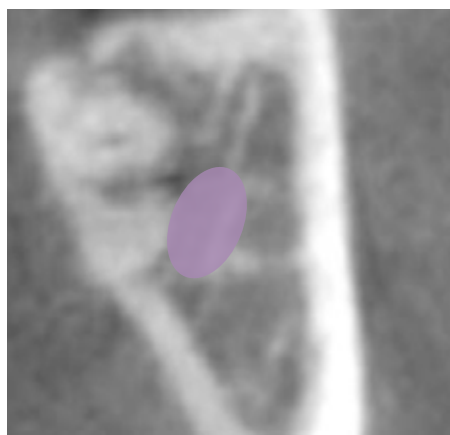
An ICat CBCT image of an M3M root proximal and lingual to the IDC (purple) with the lack of lingual plate.
